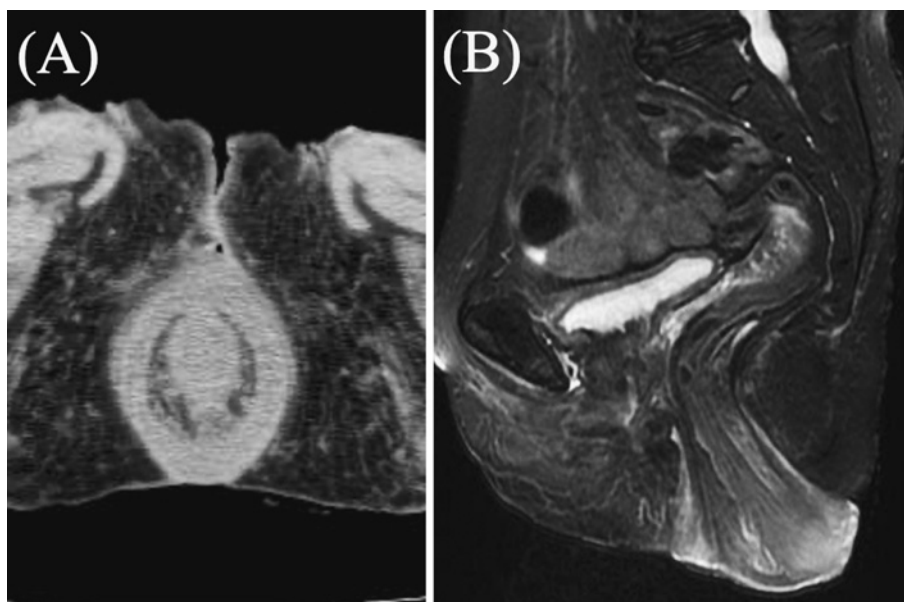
(A) Pelvic computed tomography shows rectal wall thickening and rectal prolapse. (B) Magnetic resonance imaging shows a rectal prolapse.
